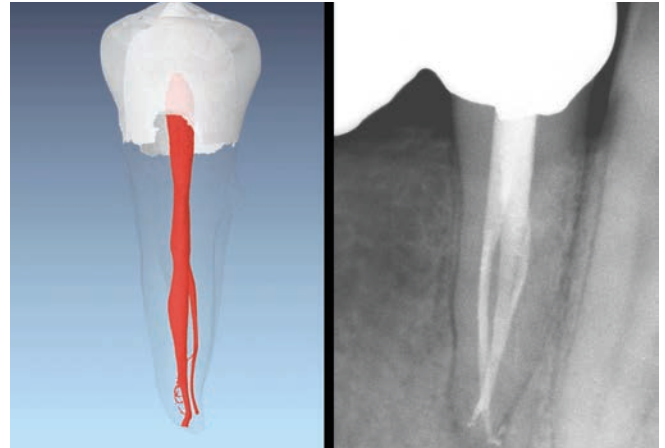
A μ CT image of a mandibular bicuspid (courtesy of Dr. Frank Paque; Zurich, Switzerland). A post-operative film demonstrates similar complex anatomy.
